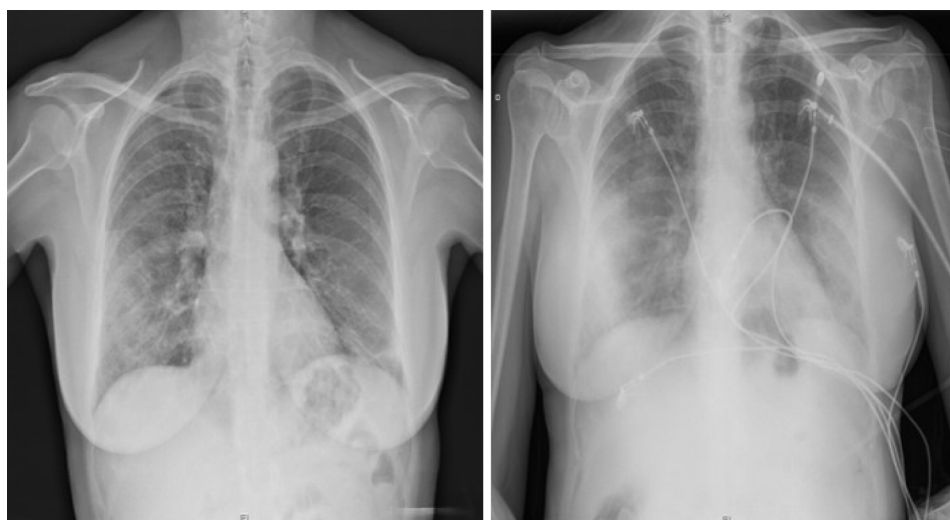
Chest X-ray findings in a 60-year-old woman with confirmed severe acute respiratory syndrome coronavirus-2 pneumonia (positive RT-PCR test). PA X-ray (left) with patchy right mid-to-lower and left lower lung opacities. AP X-ray (right) with peripherally distributed bilateral lung opacities.
